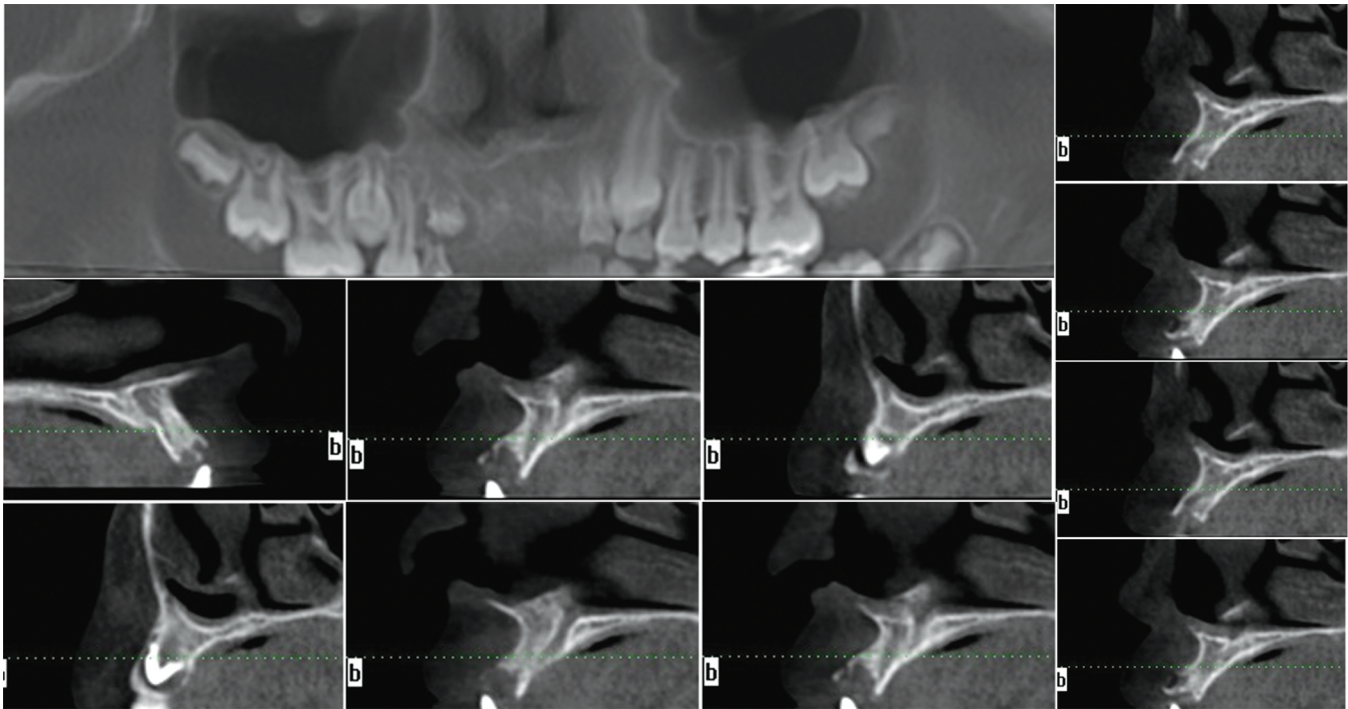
CBCT shows destruction of the labial cortical plate and remaining root
